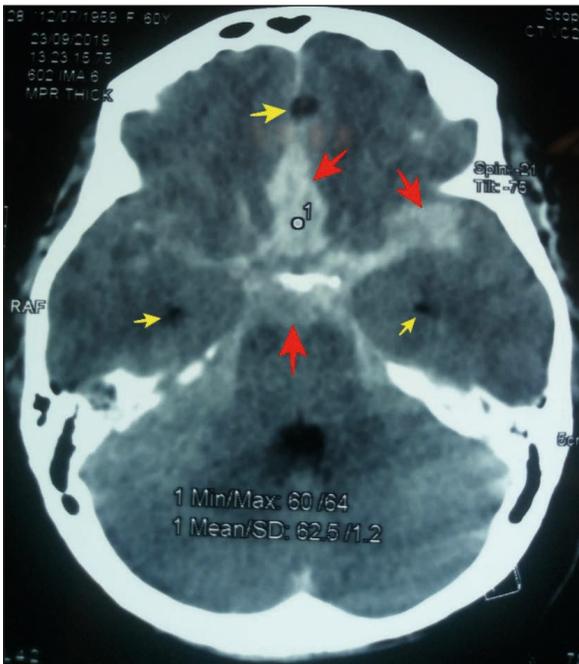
Non-contrast brain CT (September 23rd, 2019) at admission showing bleeding in the basal cisterns, Sylvian fissures and surrounding The Circle of Willis (red arrows); some hypodense lesions with cystic appearance (yellow arrows). Images are compatible with Fisher grade 4 SAH and multiple active NCC.
